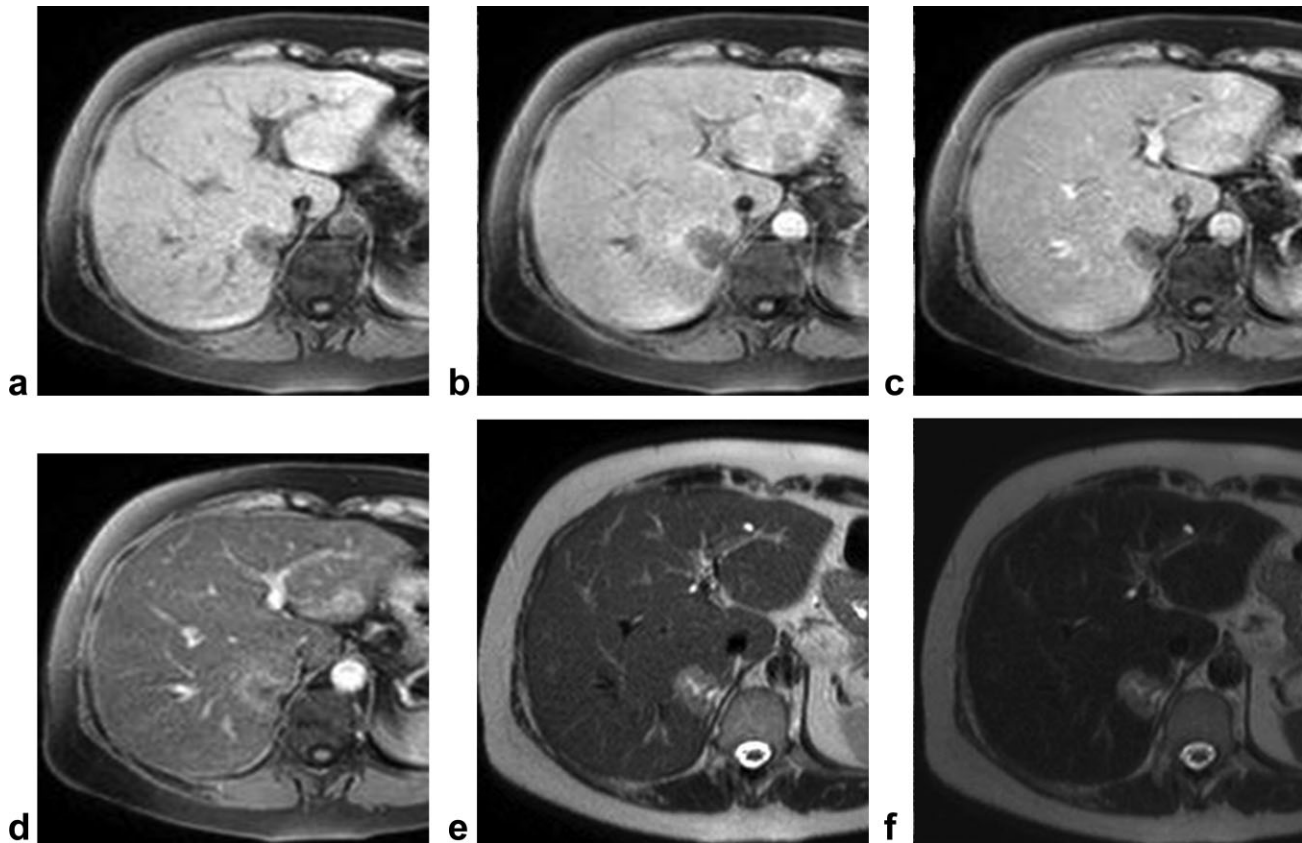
a–f: Liver metastasis (from colon cancer). On the unenhanced T1-weighted VIBE acquisition, in the medial part of the VII segment, a nodule hypointense versus surrounding parenchyma, is visible (a). After slow bolus Resovist administration, no enhancement can be detected on the arterial and portal phases (b,c), while on the 10-min T1 image (d) a peripheral ring of enhancement due to the compressed adjacent liver parenchyma, is demonstrable. On the unenhanced HASTE T2-weighted sequence (e), the lesion appears hyperintense versus liver parenchyma, with central necrotic scar. No signal intensity change, also at quantitative analysis, is demonstrable on the 10-min contrast-enhanced acquisition (f), where the nodule appears more hyperintense due to the signal decrease of the normal parenchyma.
